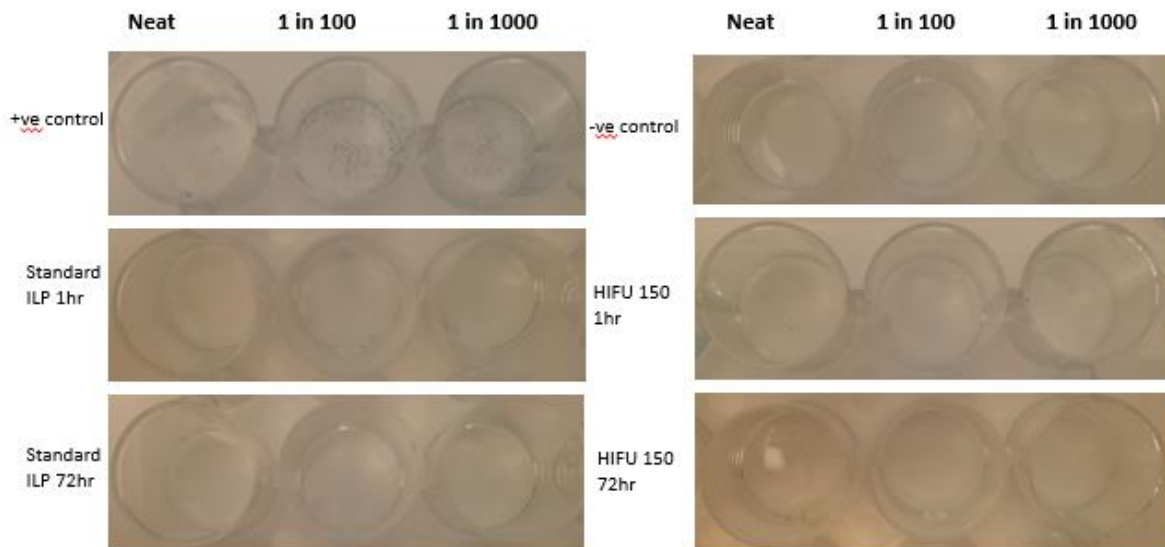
Pictures from the VPAs of two different cohorts – a cohort without exposure to ultrasound (Standard ILP) and a cohort with the combined treatment at 150W of exposure. There are three wells per sample. The first well is the undiluted lysate from the tumour (Neat) followed by 1 in 100 and 1 in 1000 dilutions of the lysate. The positive control is the stock of virus used at the same dilution for each perfusion.
